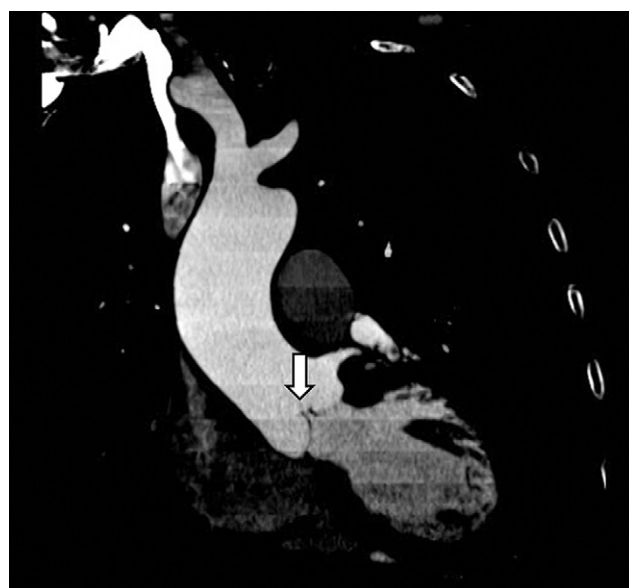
Multidetector computed tomography left ventricular outflow tract view of the aortic valve and ascending aorta in mid-diastole show malcoaptation of the aortic valve leaflets (arrow) because of annuloaortic ectasia, resulting in central aortic regurgitation.
